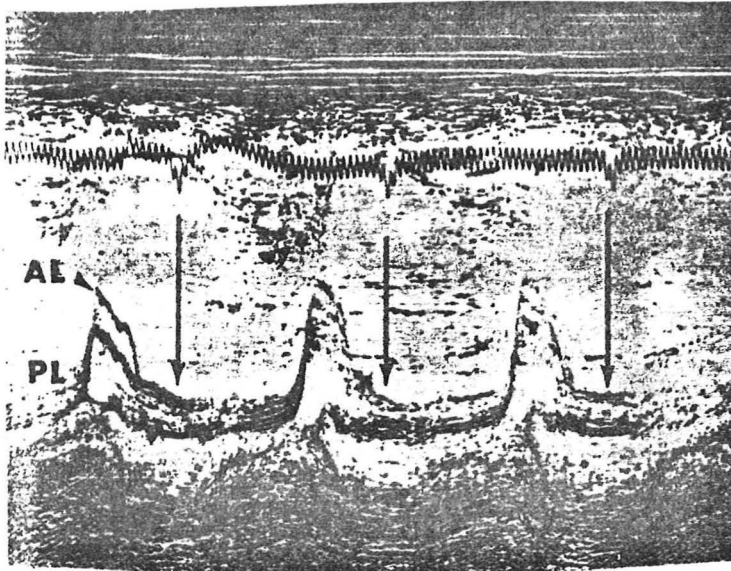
Premature mitral valve closure on an echocardiogram obtained from a patient with acute aortic regurgitation. The arrows indicate the normal point of mitral valve closure. AL=anterior leaflet; PL=posterior leaflet.
